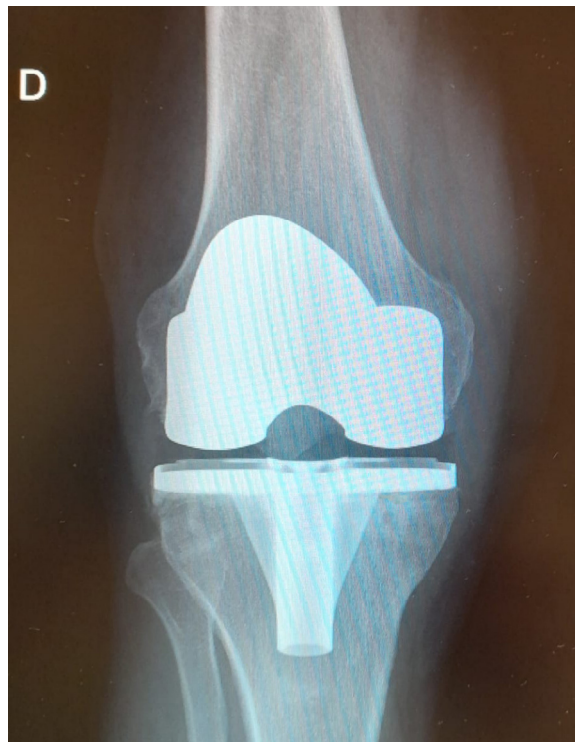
Preoperative AP radiography of patient 1.
